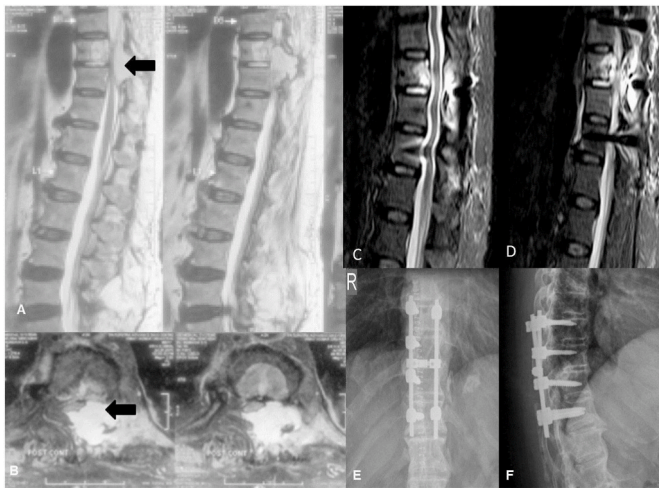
56-year-old male with persistent back pain and progressive spastic paraparesis. A: Sagittal T2w MRI showing a hyperintense lesion predominantly involving the posterior columns of T9 vertebral body with extension into the spinal canal. (Arrow) B: Axial MRI showed that the lesion has involved the pedicles and posterior elements on the left side. C and D: Postoperative sagittal MRI showing adequate decompression of the thoracic cord. E and F: Postoperative X rays at 24 months follow-up showing the implant in-situ.
